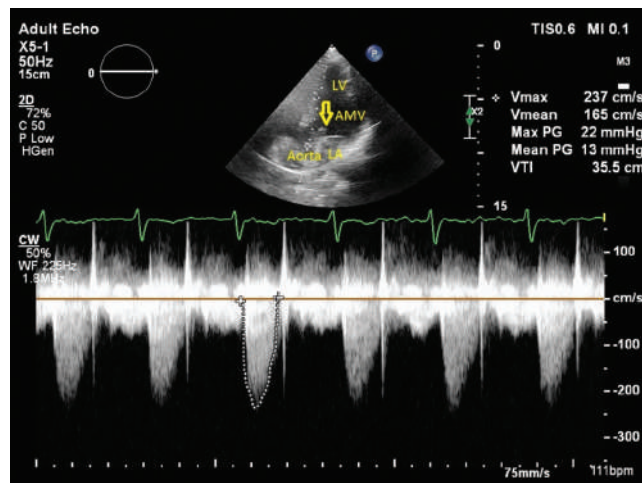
The image presents transthoracic echocardiography in the 5-chamber view. Continuous-wave (CW) Doppler shows a mild increase in the LVOT (peak gradient=22 mmHg). The arrow shows the LVOT mass. LV, Left ventricle; LA, Left atrium; AMV, Accessory mitral valve; LVOT, Left ventricular outflow tract
